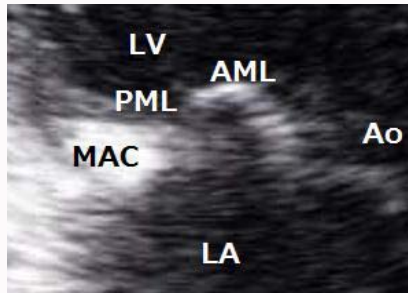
Echocardiography at first admission.
